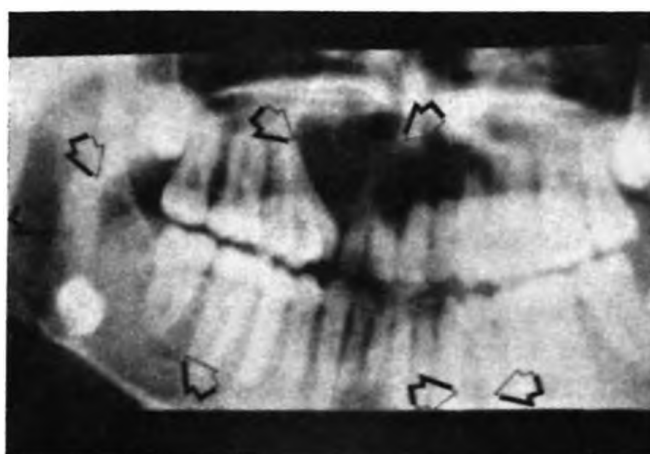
Panoramic radiograph of the second patient revealing multiple odontogenic jaw cysts.
